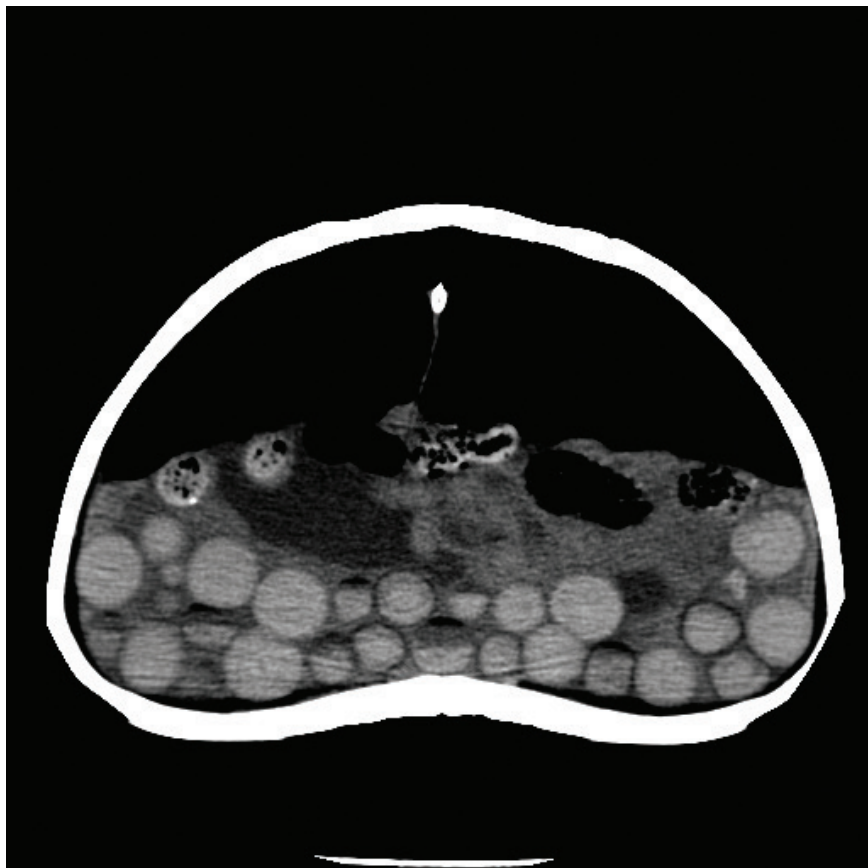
A CT scan image of the tortoise demonstrating a significant number of follicles of various sizes.
